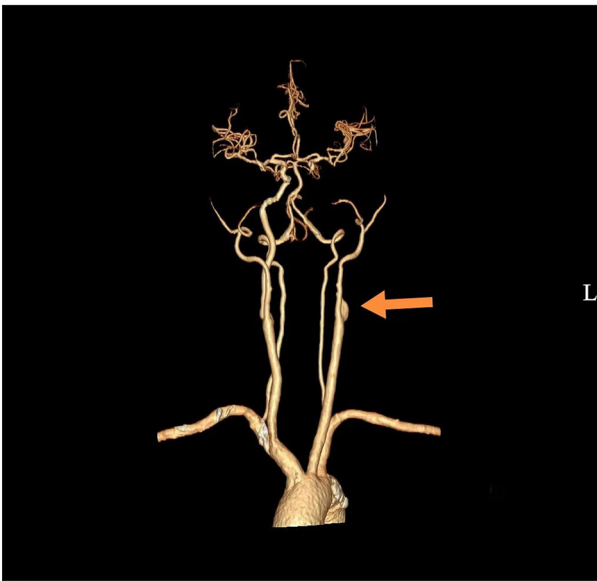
Cerebral computed tomography angiography demonstrating patent bilateral common carotid, internal carotid, external carotid, vertebral, middle cerebral, anterior cerebral, and posterior cerebral arteries, as well as the basilar artery and its branches. The arterial walls are irregular with calcified plaques, and the vessel lumens display multifocal narrowing. Occlusion of the left internal carotid artery and approximately 70%-80% stenosis at the origin of the left vertebral artery are present.
